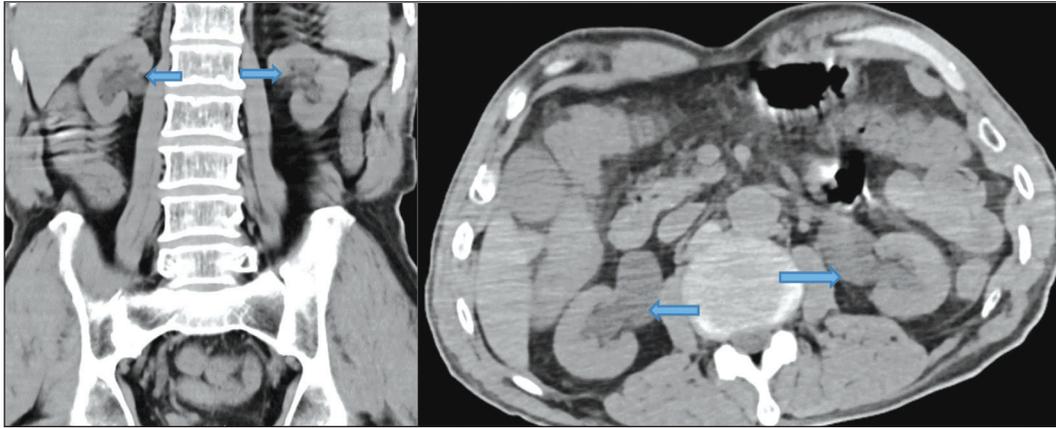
Coronal and axial section of the abdominal computed tomography demonstrates bilateral Grade 2 hydronephrosis (blue arrows).
